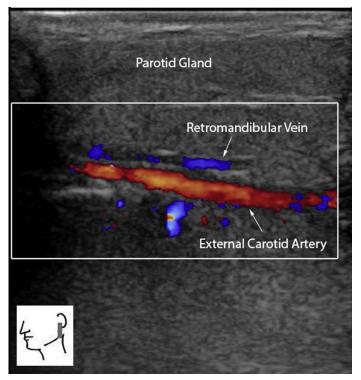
Longitudinal sonogram of the left parotid showing normal anatomy of the retromandibular vein and external carotid artery.
